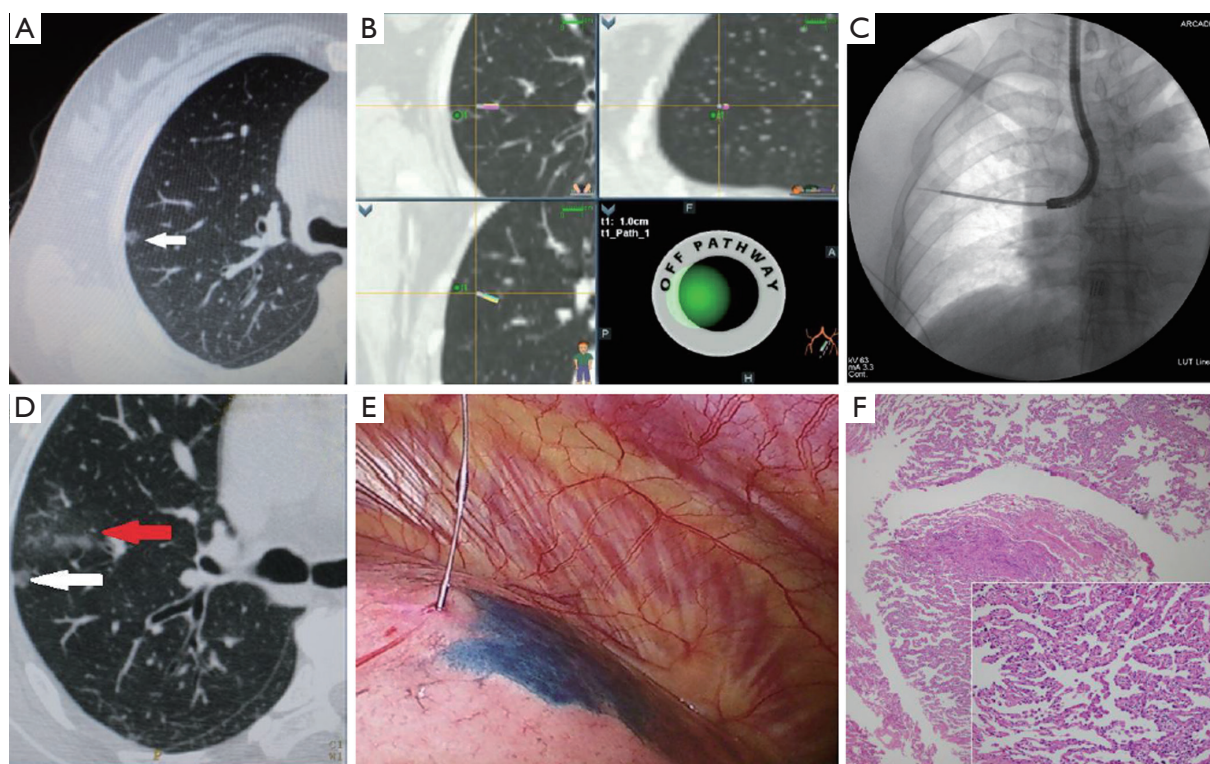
(A) It was the preoperative CT scan of the patient, which showed a ground glass opacity (white arrow) in the right upper lobe; (B) it was the real-time navigation screen when the distance between the sensor probe and the lesion was nearest; (C) injection of methylene blue through extended working channel (EWC) under the guidance of X fluoroscopy; (D) it was the chest CT scan after injection of methylene blue, some floccules like cloud (red arrow) occurred after injection of methylene blue; (E) the lesion could be seen located in the region between methylene blue and the hookwire during the process of the VATS; (F) the pathology result showed it was adenocarcinoma (40x).
